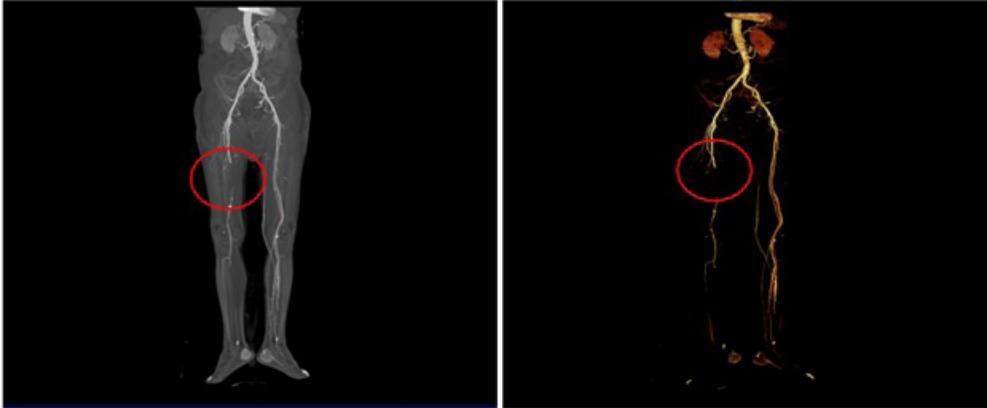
CT angiography of aorta and iliofemoral arteries: Complete occlusion of the right superficial femoral artery extended to the popliteal artery
